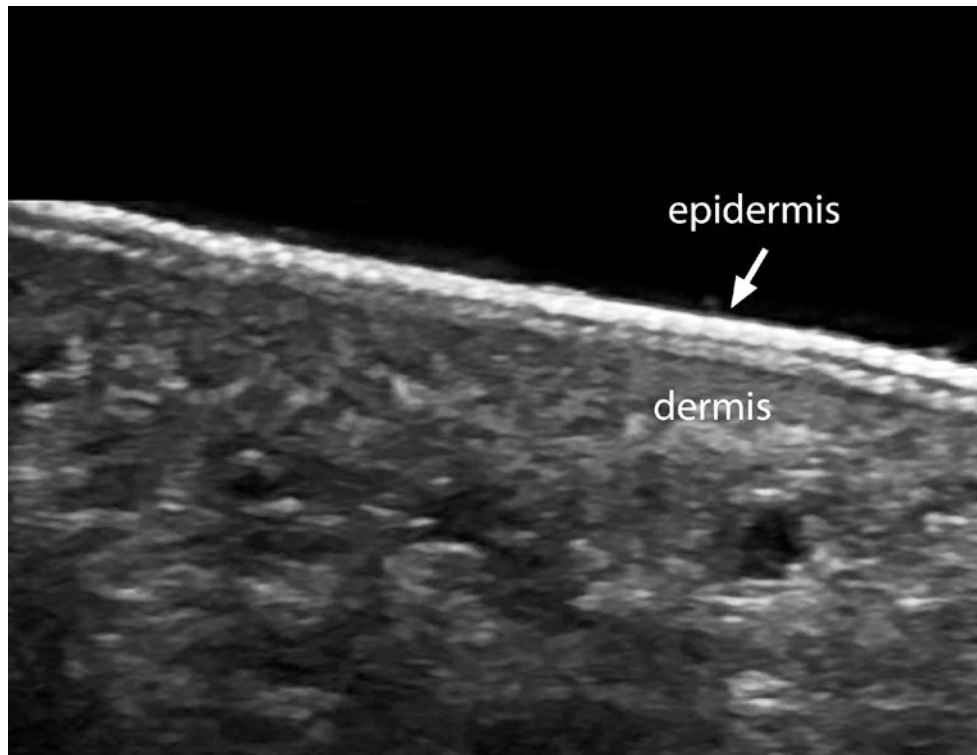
Normal ultrasound anatomy of the glabrous epidermis (plantar region). Notice the bilaminar hyperechoic structure of the epidermis.
